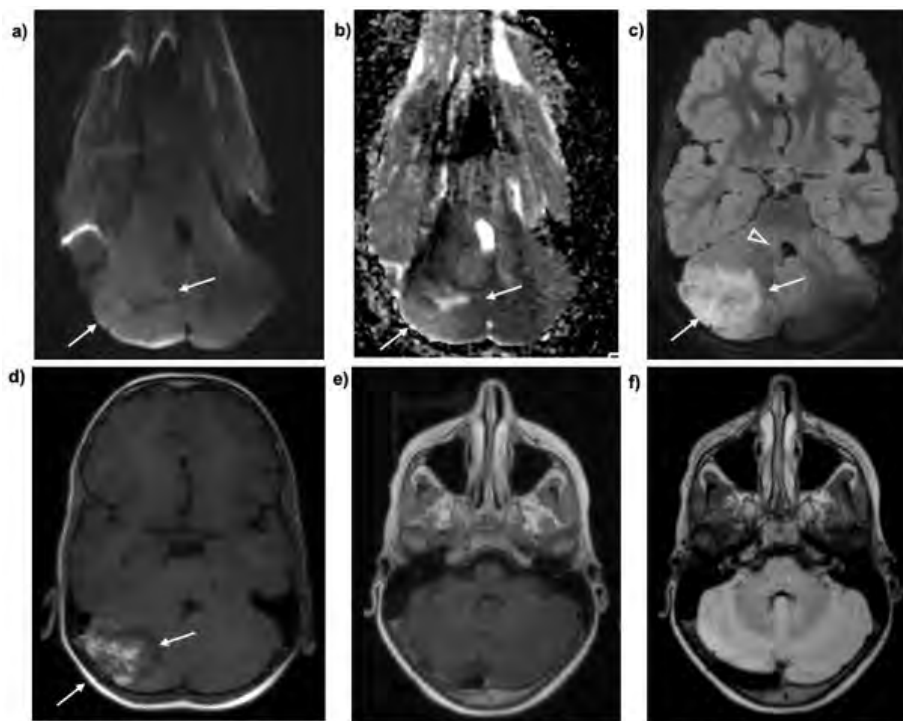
MRI Brain with and without IV contrast at time of presentation (a-d) and at 8 month follow up, after resolution of symptoms (e, f). a, b, axial DWI and ADC demonstrate facilitated diffusion (arrows), c, axial T2 FLAIR with expansive heterogeneous T2 hyperintense signal in the right cerebellum (arrows) causing mass effect on the 4th ventricle (open arrow), d, axial T1 post-contrast demonstrates enhancement along the cerebellar folia (arrows), e, f, axial T1 post-contrast and T2 FLAIR at 8 month follow up demonstrate resolution of signal abnormalities.
